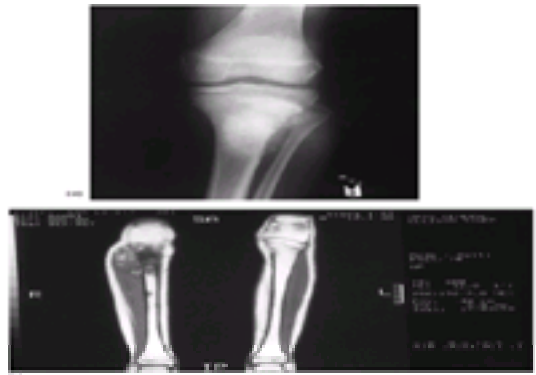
Osteosarcoma: (a) a typical plain radiograph of an osteosarcoma (image is reversed); there is new bone formation with extension into the soft tissue. (b) On MRI the tumor extension is seen and a 'skip' lesion in the tibial diaphysis is found.
